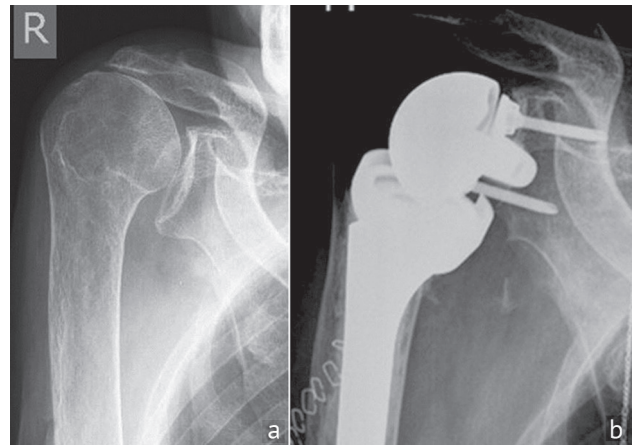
Radiographs of the shoulder joint of patient A.: a prior to TSA; b 4 days postsurgery
